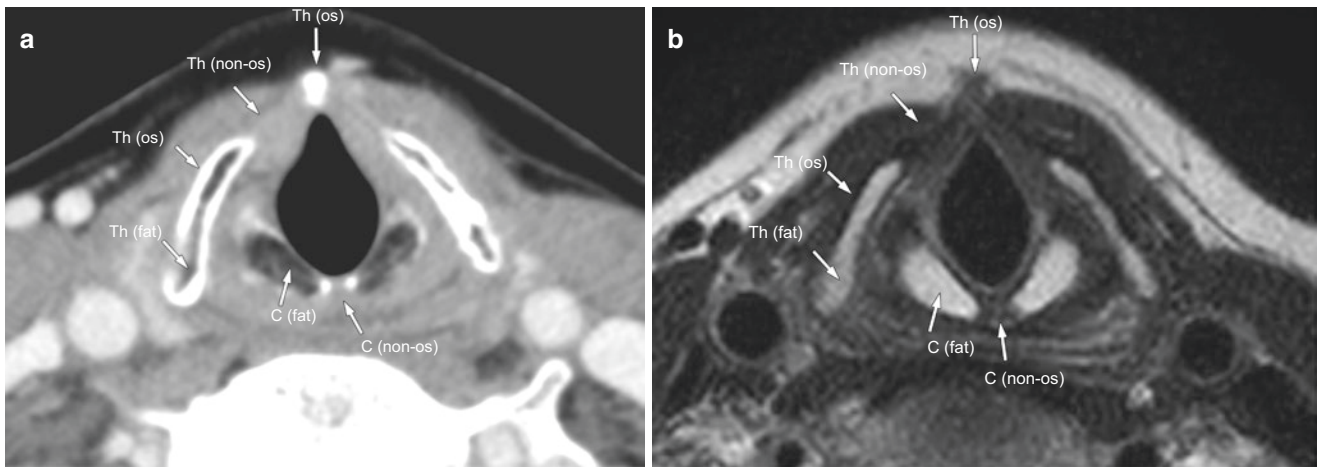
Anatomy of the laryngeal cartilage. Contrast-enhanced CT (a) and T2-weighted image (b). *Th* thyroid cartilage, *C* cricoid cartilage, *os* ossified, *non-os* fat fat marrow
